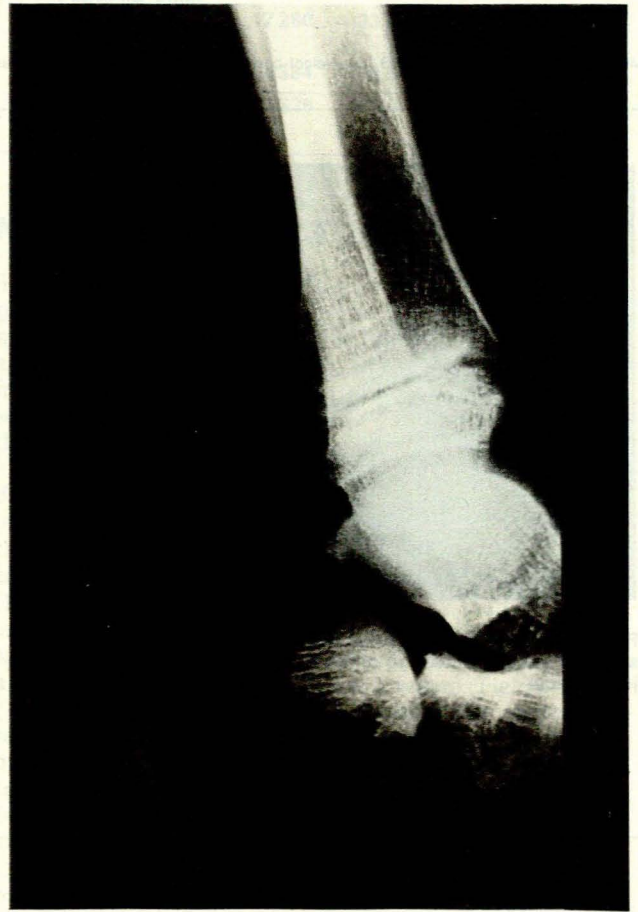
Lateral radiograph showing an intra-articular fracture of the calcaneum in a 10-year-old child.
